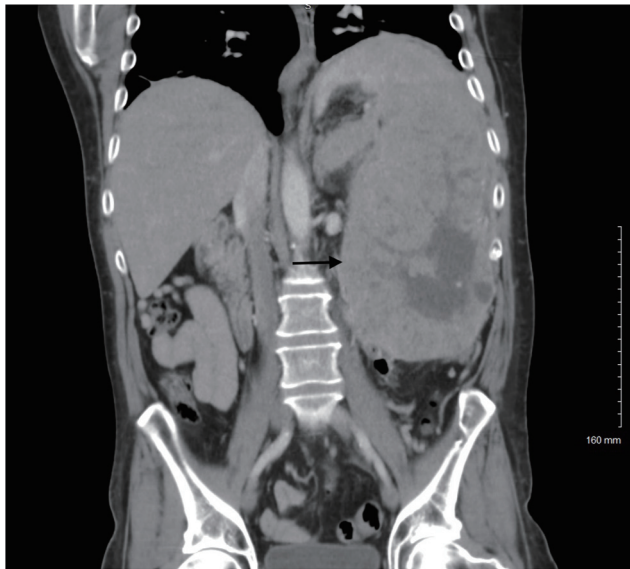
Computed tomography imaging shows a 22-centimeter, heterogeneous splenic mass with central necrosis.
